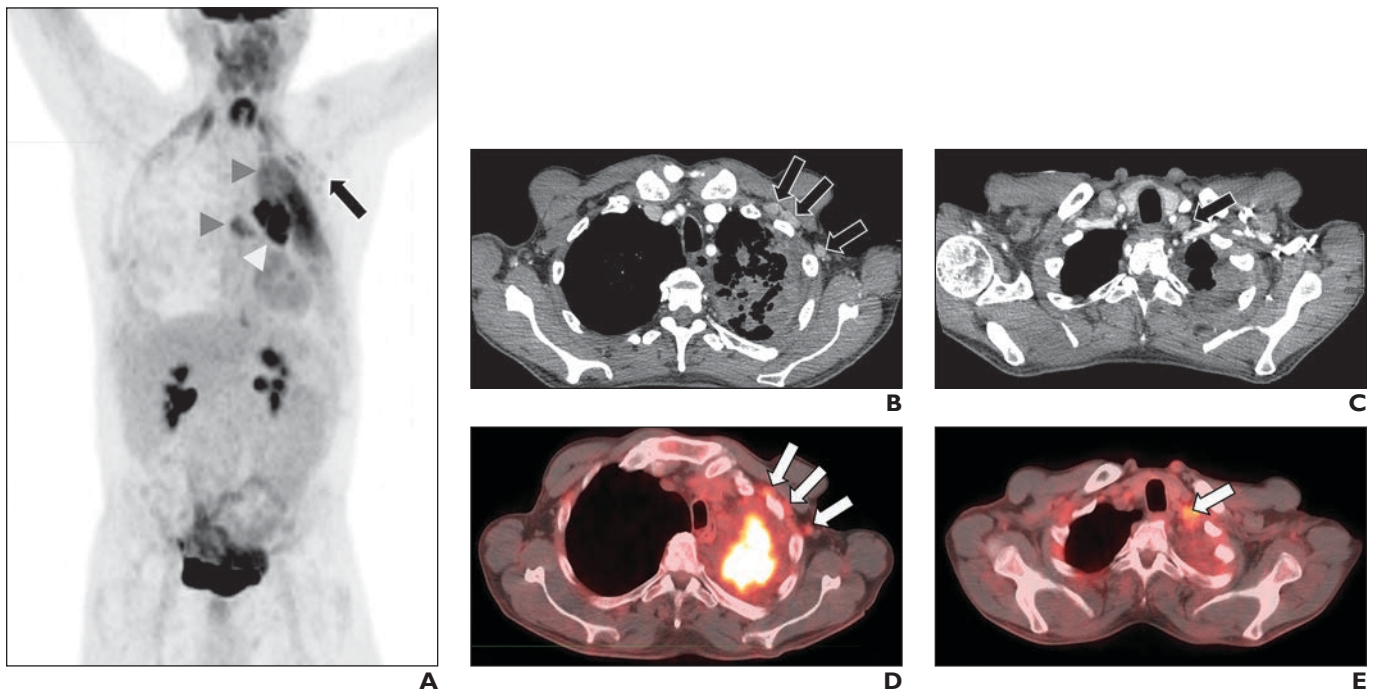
59-year-old man with newly diagnosed lung cancer 2 weeks after COVID-19 vaccination (brand not specified). A–E, Maximum intensity projection image (A), axial contrast-enhanced CT images of axillary levels 1 and 2 (B) and supraclavicular (C) lymph nodes, and fusion images of axillary levels 1 and 2 (D) and supraclavicular (E) lymph nodes from FDG PET/CT show enhancing FDG-avid left axillary levels 1 and 2 (arrows, B and D) and supraclavicular lymphadenopathy (arrows, C and E). Lower cervical levels were also FDG avid (not shown). Although findings in axillary nodes are likely related to vaccination, lower cervical and supraclavicular lymphadenopathies are indeterminate in this patient with left upper lobe squamous cell carcinoma (white arrowhead, A) and ascending nodal involvement (gray arrowheads, A).
